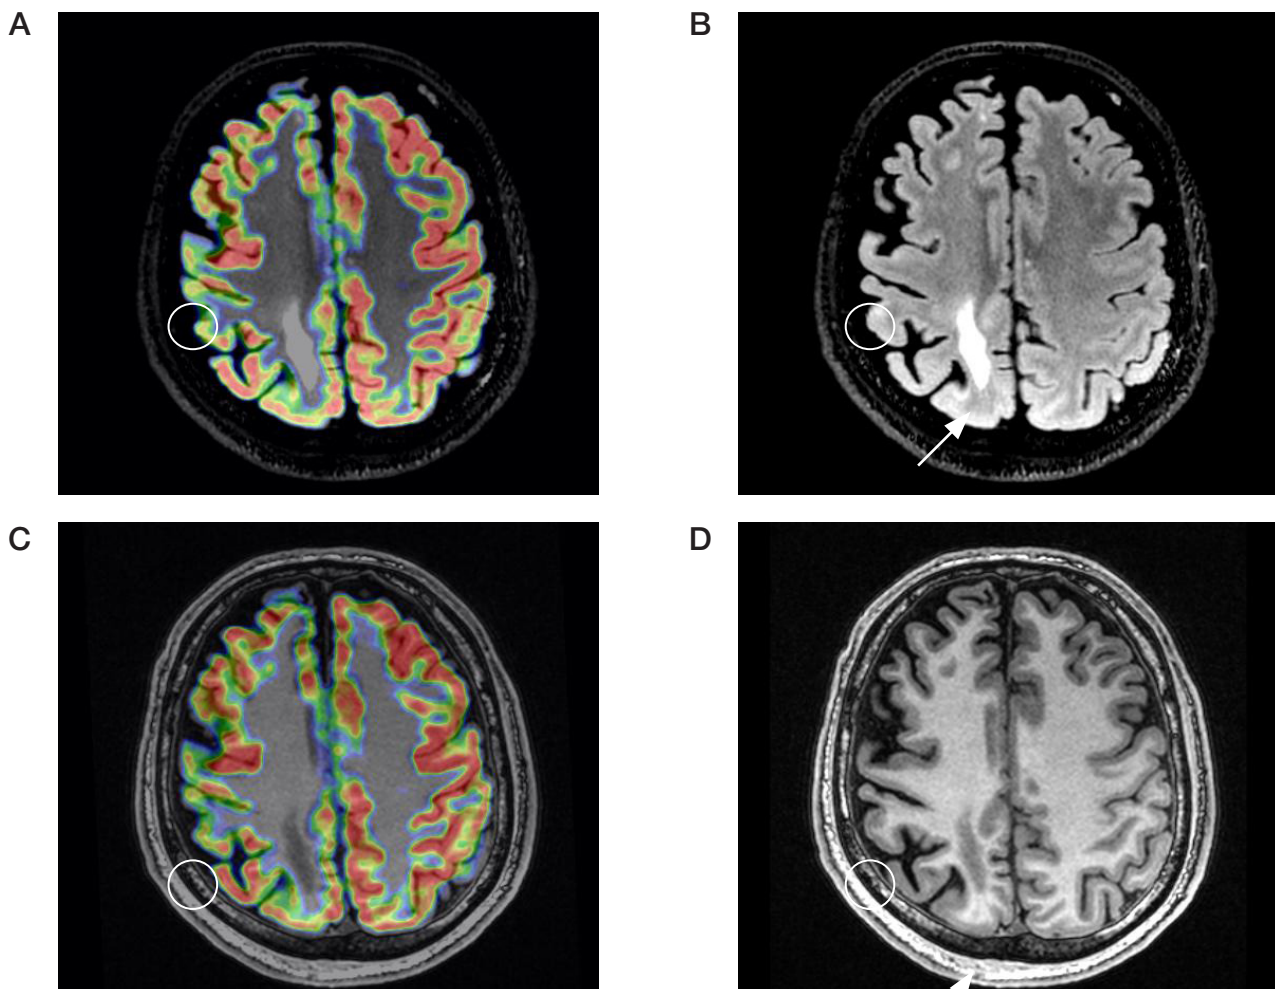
^{18}F -FDG-PET-MRI of the brain in patient with pharmacoresistant epilepsy and unsatisfactory outcome of epilepsy surgical treatment. A, C: area of hypometabolism in the dorsolateral cortex of the right frontal lobe (circle). Brain MRI: axial FLAIR (B), IR-FSPGR (D). Focal cortical thickening with FLAIR hyperintensity in the area of hypometabolism (circle). Postsurgical structural brain changes in the paramedian area of the right parietal lobe (arrow)
